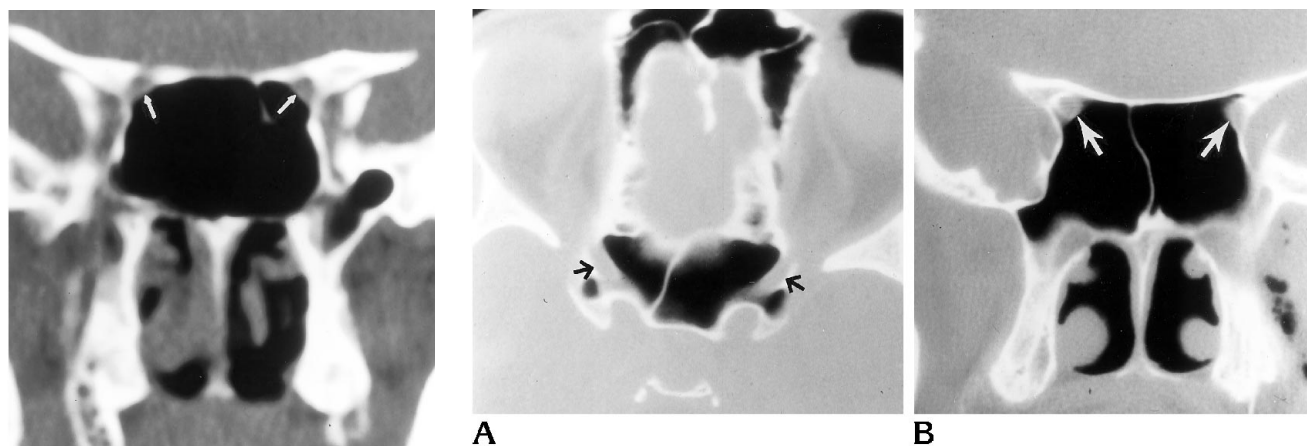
Type 2 optic nerve. Coronal CT scan with bilateral optic nerves (arrows) penetrating the contour of the sphenoidal sinus. There is an absence of bone density along the medial border of the optic canal (dehiscence).
